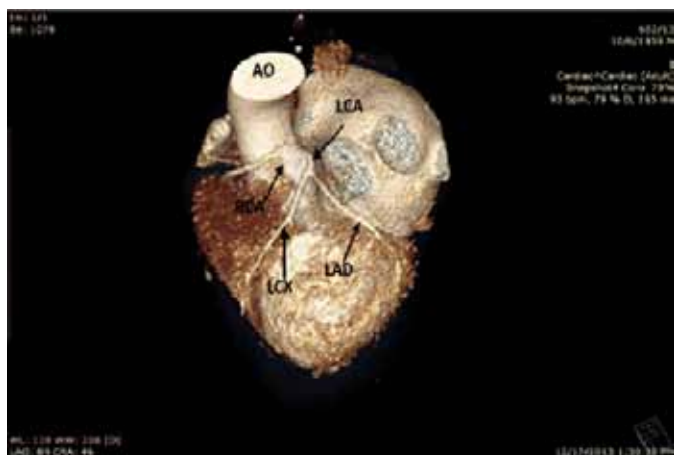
Computed tomography angiography reconstruction. Three dimensional view of coronary artery origin. The origin of the right coronary artery is from the left coronary sinus. AO = Aorta; LAD = Left descending coronary artery; LCA = Left coronary artery; LCx = Left circumflex coronary artery. RCA = right coronary artery.
